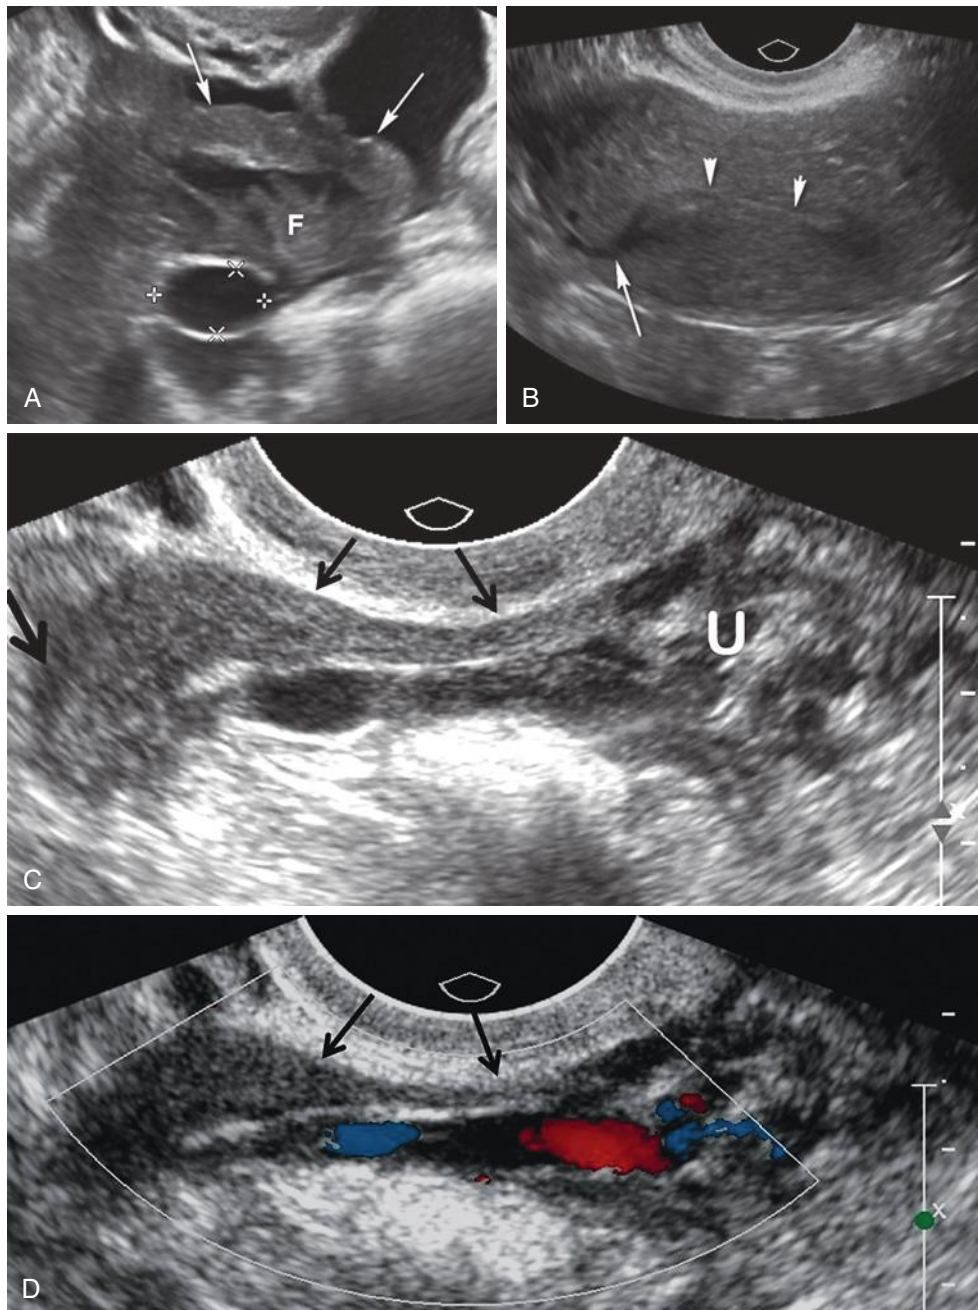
Normal fallopian tubes. A, A small amount of anechoic free fluid surrounds the fallopian tube (arrows). Note anechoic paratubal cyst (calipers) adjacent to the fimbriated end (F). B, A partial coronal view of the uterine fundus demonstrating a trace amount of fluid (arrow) in the interstitial portion of the right fallopian tube; endometrium is indicated by arrowheads. C, Normal fallopian tube (arrows) coursing from the cornua of the uterus (U) above the anechoic uterine vessels to the right adnexa. Note that the more medial isthmic portion (thin arrows) of the tube is the thinnest segment, whereas the fimbriated end (thick arrow), which usually sits above or “caps” the ovary, is the thickest segment. D, Color Doppler image of the same patient in C demonstrating the fallopian tube (arrows) above the uterine vessels (blue/red).
